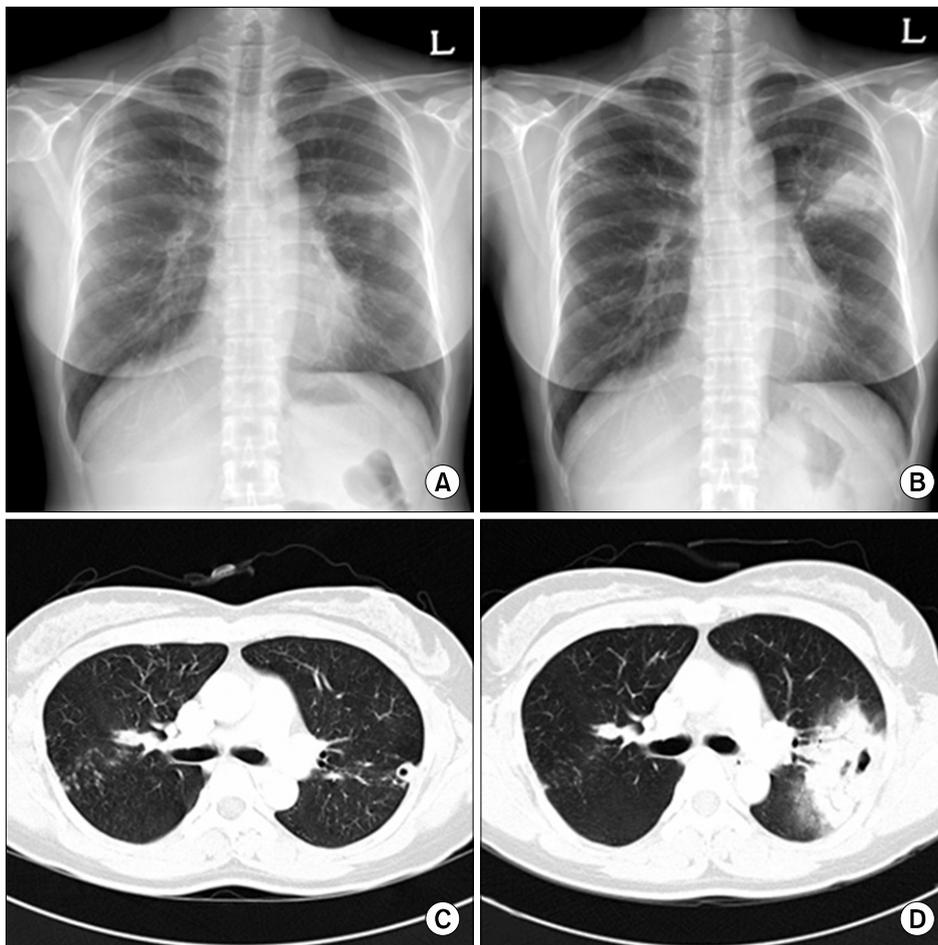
(A) Chest radiograph on admission, Multiple aggregated nodules and a consolidative lesion were noted on the right and left upper lobes, respectively. (B) Chest radiograph 25 days after admission (before surgical resection). The consolidative lesion on the left upper lobe had become aggravated. (C) Chest CT scan 79 days before admission. A small cavitary nodule was noted on the left upper lobe. (D) Chest CT scan 9 days after admission. A rapidly progressive consolidative lesion was noted on the left upper lobe.
